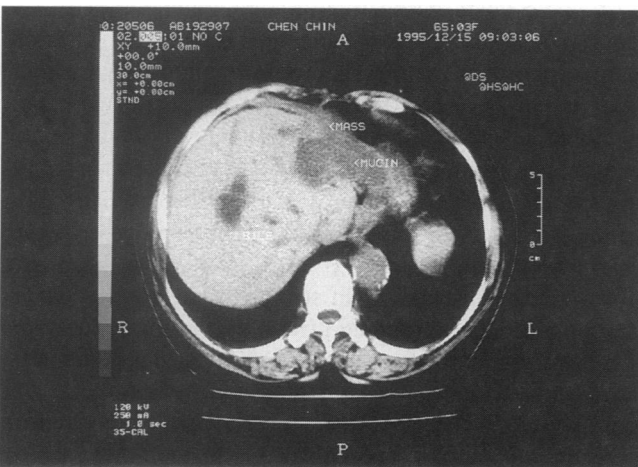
Computed tomography scan revealed a mass and mucinlike substance in the liver parenchyma with dilated intrahepatic ducts.
